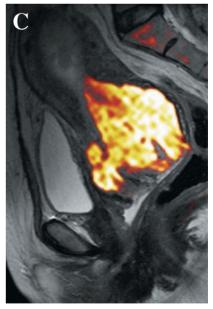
Endometrial adenocarcinoma in a 51 year-old woman. Sagittal (A) preoperative T2-weighted, (B) contrast enhanced T1 weighted, (C) and fused T2-weighted and diffusion-weighted MRI show a large, heterogeneous tumor situated primarily at the endocervical canal and extending to the endometrial canal. There is tumor invasion of the myometrium and cervical stroma. Differentiation of the tumor origin using T2WI and DCE may be difficult. The ADC value of this tumor measures 67.8 x 10⁻⁵ mm²/sec, suggesting an endometrial origin. Biopsy confirmed the diagnosis of endometrial adenocarcinoma.
